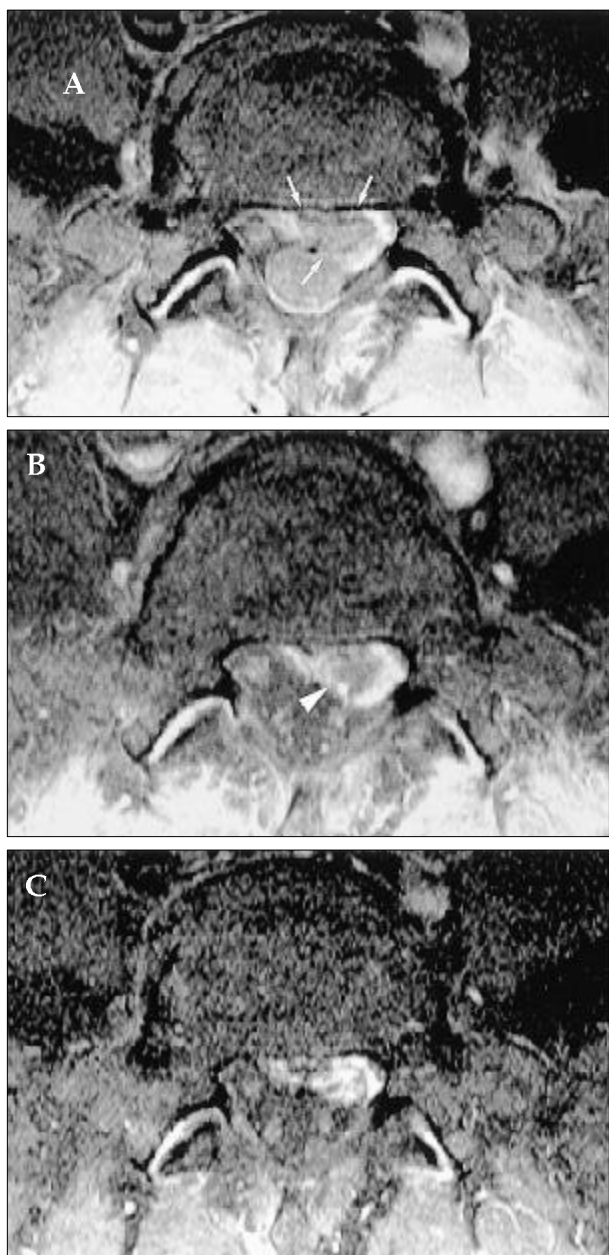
Morphologic change in a sequestered disc. Post-contrast fat suppressed axial T1-weighted images (583/12) in a 41-year-old man with left-side sciatica. A, Sequestered disc with ring-enhancement was observed in the initial study (arrows). B, A second MR imaging was performed 1.5 months later. The enhanced area had thickened and intruded into the sequestered disc materials as the size of the HNP decreased (arrow head). C, A follow-up study showed nearly complete disappearance of the sequestered disc herniation 5.5 months later. The patient showed no pain and daily activities were unaffected.
